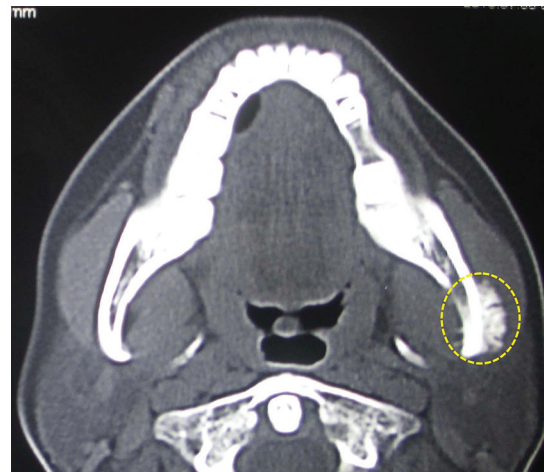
Axial computed tomography scan showing destructive lesion on left angle of mandible extending into the ramus. Codman triangle and sunray appearance seen in the margin of the lesion
